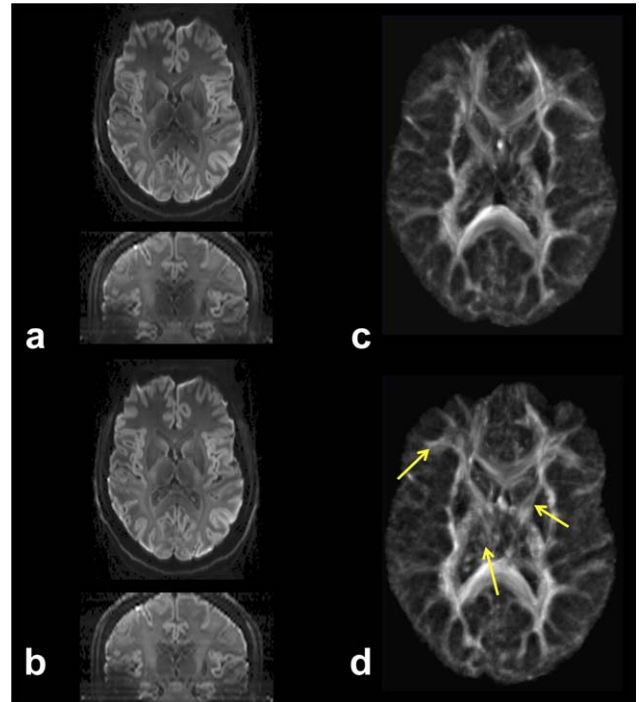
A,B: Trace-weighted images for the 68-direction DWI datasets acquired with conventional ST and MASE respectively, showing reduced signal intensity for ST in regions near the thalamus (coronal reformatted images are also shown). C,D: Track density imaging derived from whole-brain tractography performed using 10^6 tracks and a resolution of 1.5 mm^3 . Arrows point to increased fiber density for MASE, observed in central and frontal regions, as well as in the internal capsule.
